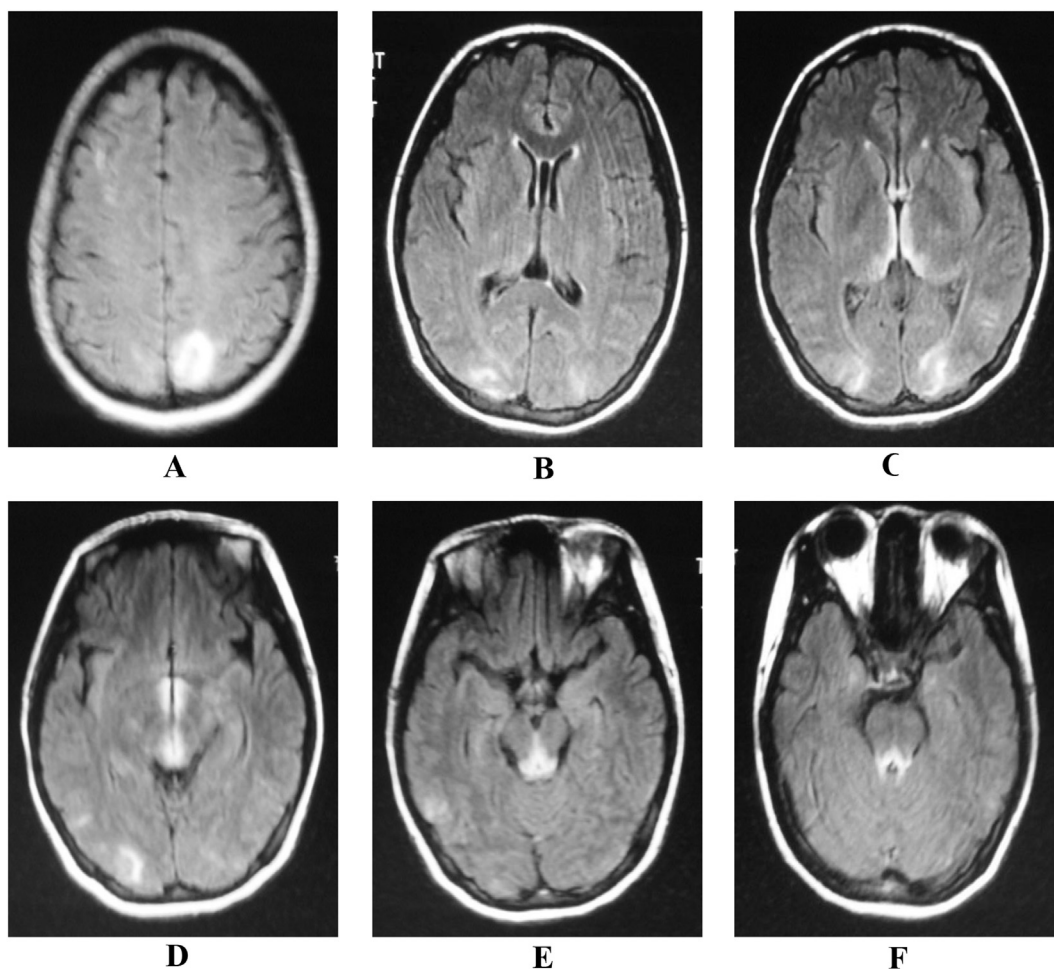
Axial FLAIR images showing asymmetric hyperintensities in bilateral occipital lobe (A, B), surrounding third ventricle and posteromedial thalami (C, D), periaqueductal areas (E, F).
